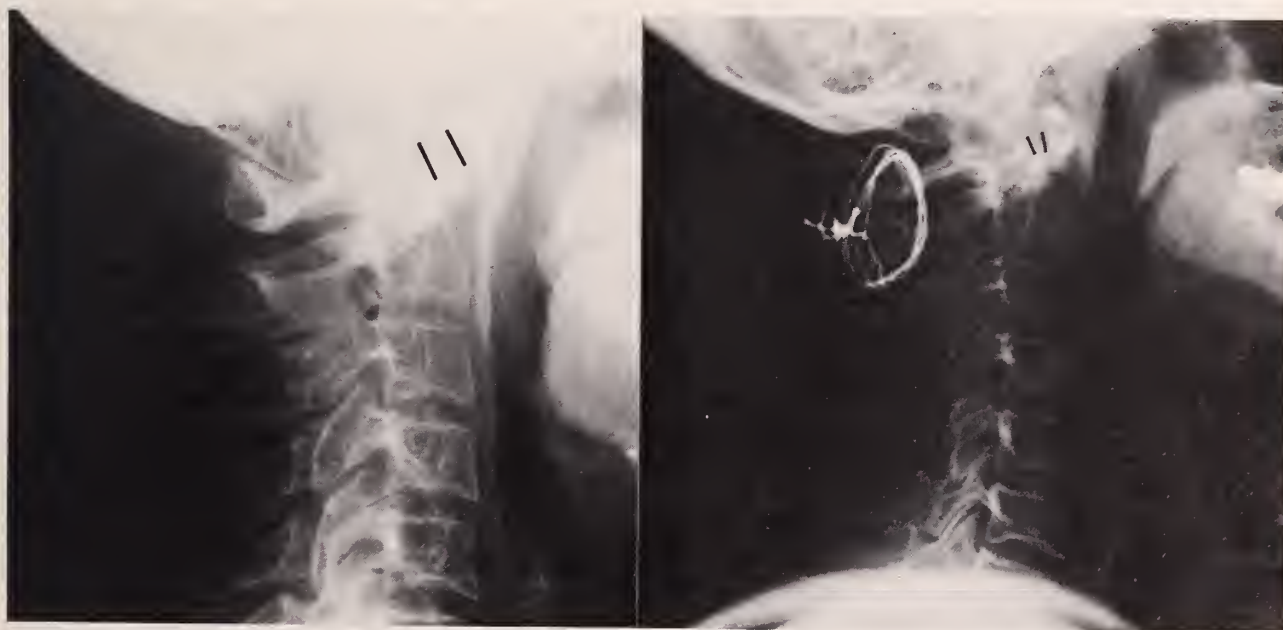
(Left) Preoperative lateral radiograph demonstrating 8 mm. of atlantoaxial subluxation. (Right) Postoperative lateral radiograph demonstrating C1-C2 fusion wires and an acceptable atlantoaxial relationship.
